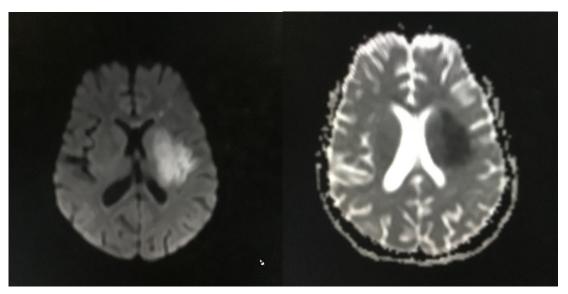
(A) DWI showing diffusion restriction in the left basal ganglia, (B) a significant signal drop on the ADC image.
